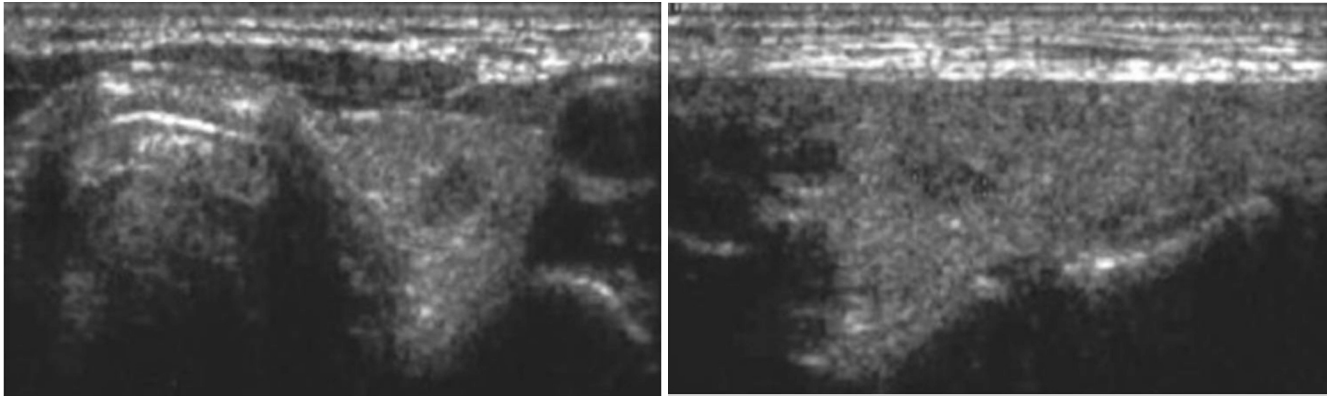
46-year-old woman with papillary carcinoma. A (axial) and B (longitudinal) sonograms of left lobe of the thyroid gland show 0.9 cm, taller than wide, well-defined spiculated, hypoechoic nodule with cystic degeneration and peripheral hypoechoic rim.
